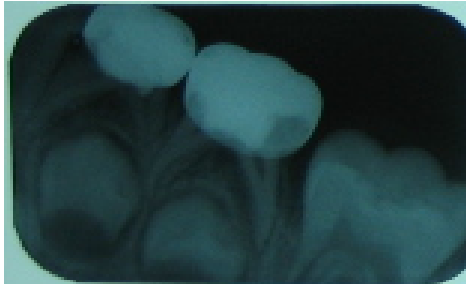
Radiographic view shows no pathologic sign of failure following pulp treatment using LLLT in 12 months follow up
